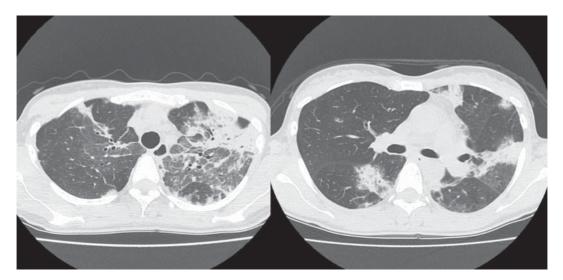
Chest computed tomography on admission shows peripheral-dominant consolidations around the upper lobe.
